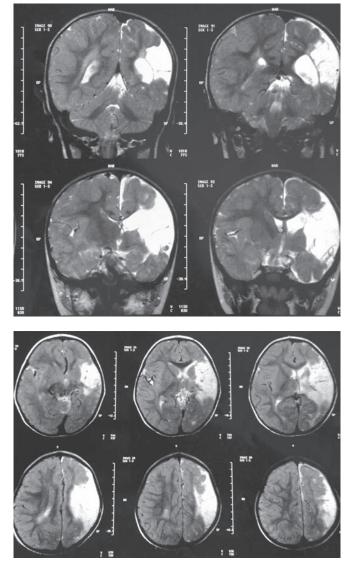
T2 weighted coronal and axial magnetic resonance imaging: large cystic encephalomalacic lesion in left hemisphere due to perinatal stroke
